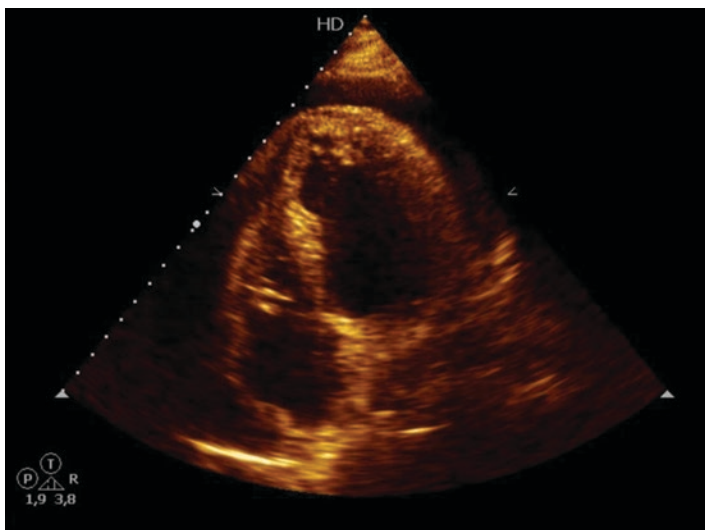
Transthoracic echocardiogram – modified four-chamber view. Visualization of the right atrium, right ventricle, and left ventricle. Abnormal echo-dense mass in the tricuspid valve. Evidence of pericardial effusion
